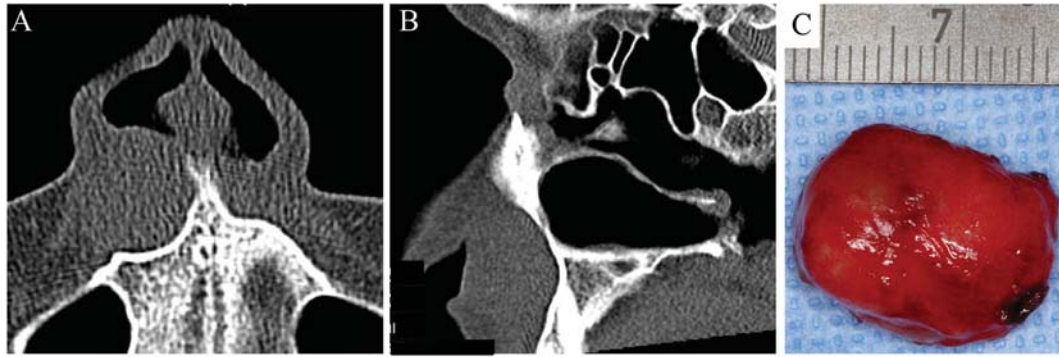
Radiographic and macroscopic findings of nasolabial cyst. On axial computed tomogram (A), the roundish lesion has caused an impression of the aperture. The adjacent cortical bone shows continuous coverage of the spongiosa. On sagittal image (B), the thinning of the aperture's curvature is remarkable. The excised cyst (C) has a firm wall.
